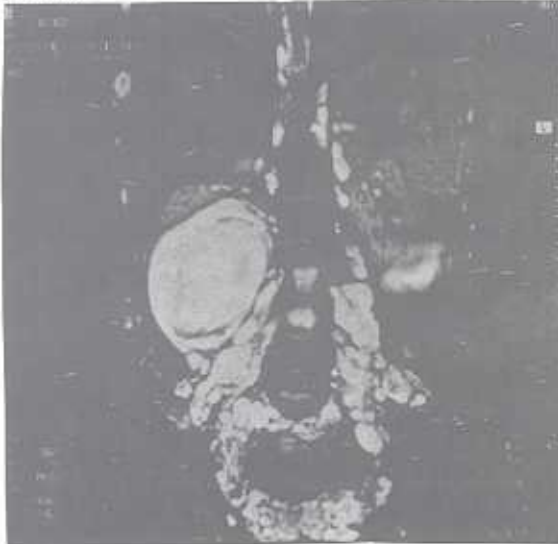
MRI of the patient showing diffuse neurofibromas and a retroperitoneal huge mass in the abdominal region.
